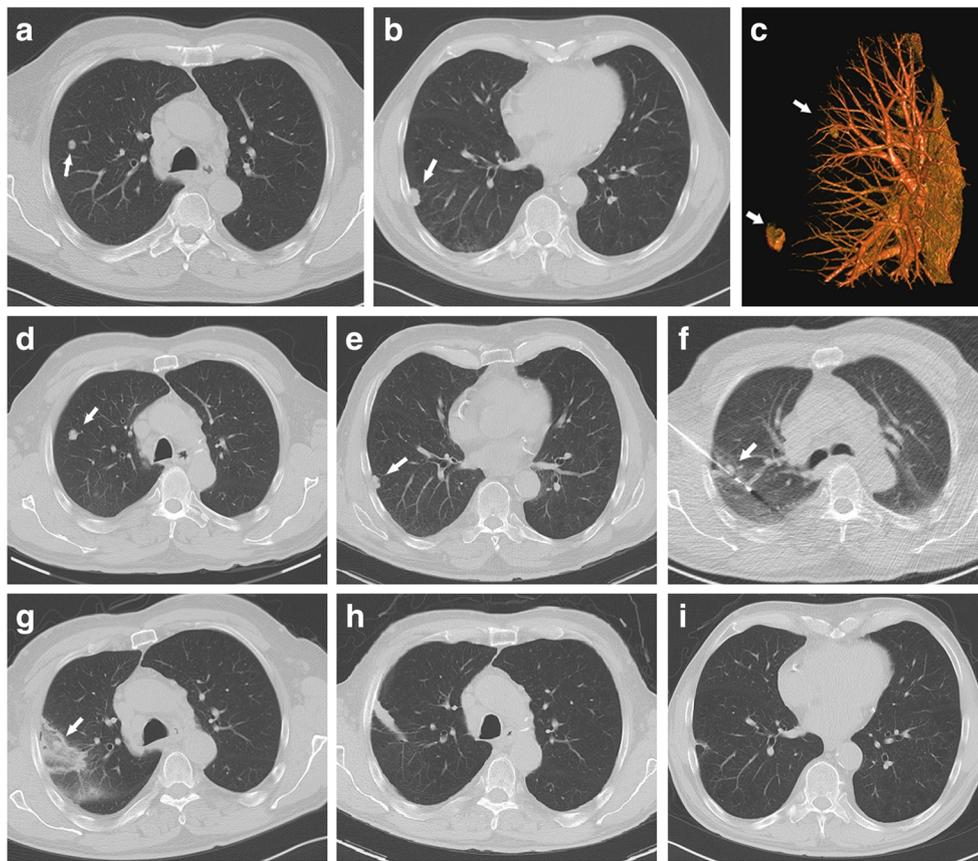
A 70-year-old male patient with unilateral lung metastases ($n=2$) of colorectal carcinoma. The patient underwent three cycles of TPCE followed by complete ablation of the two pulmonary nodules in two subsequent sessions. a, b Non-enhanced axial computed tomography (CT) of the lung after the first session of chemoembolization, demonstrating two right upper and lower lung lobes nodules measuring 10.6 and 19.4 mm in the longest diameter, respectively (arrows). c 3D reconstruction of a rotational angiogram done during the procedure demonstrating the position and blood supply of both right lung nodules and confirming their hyper
